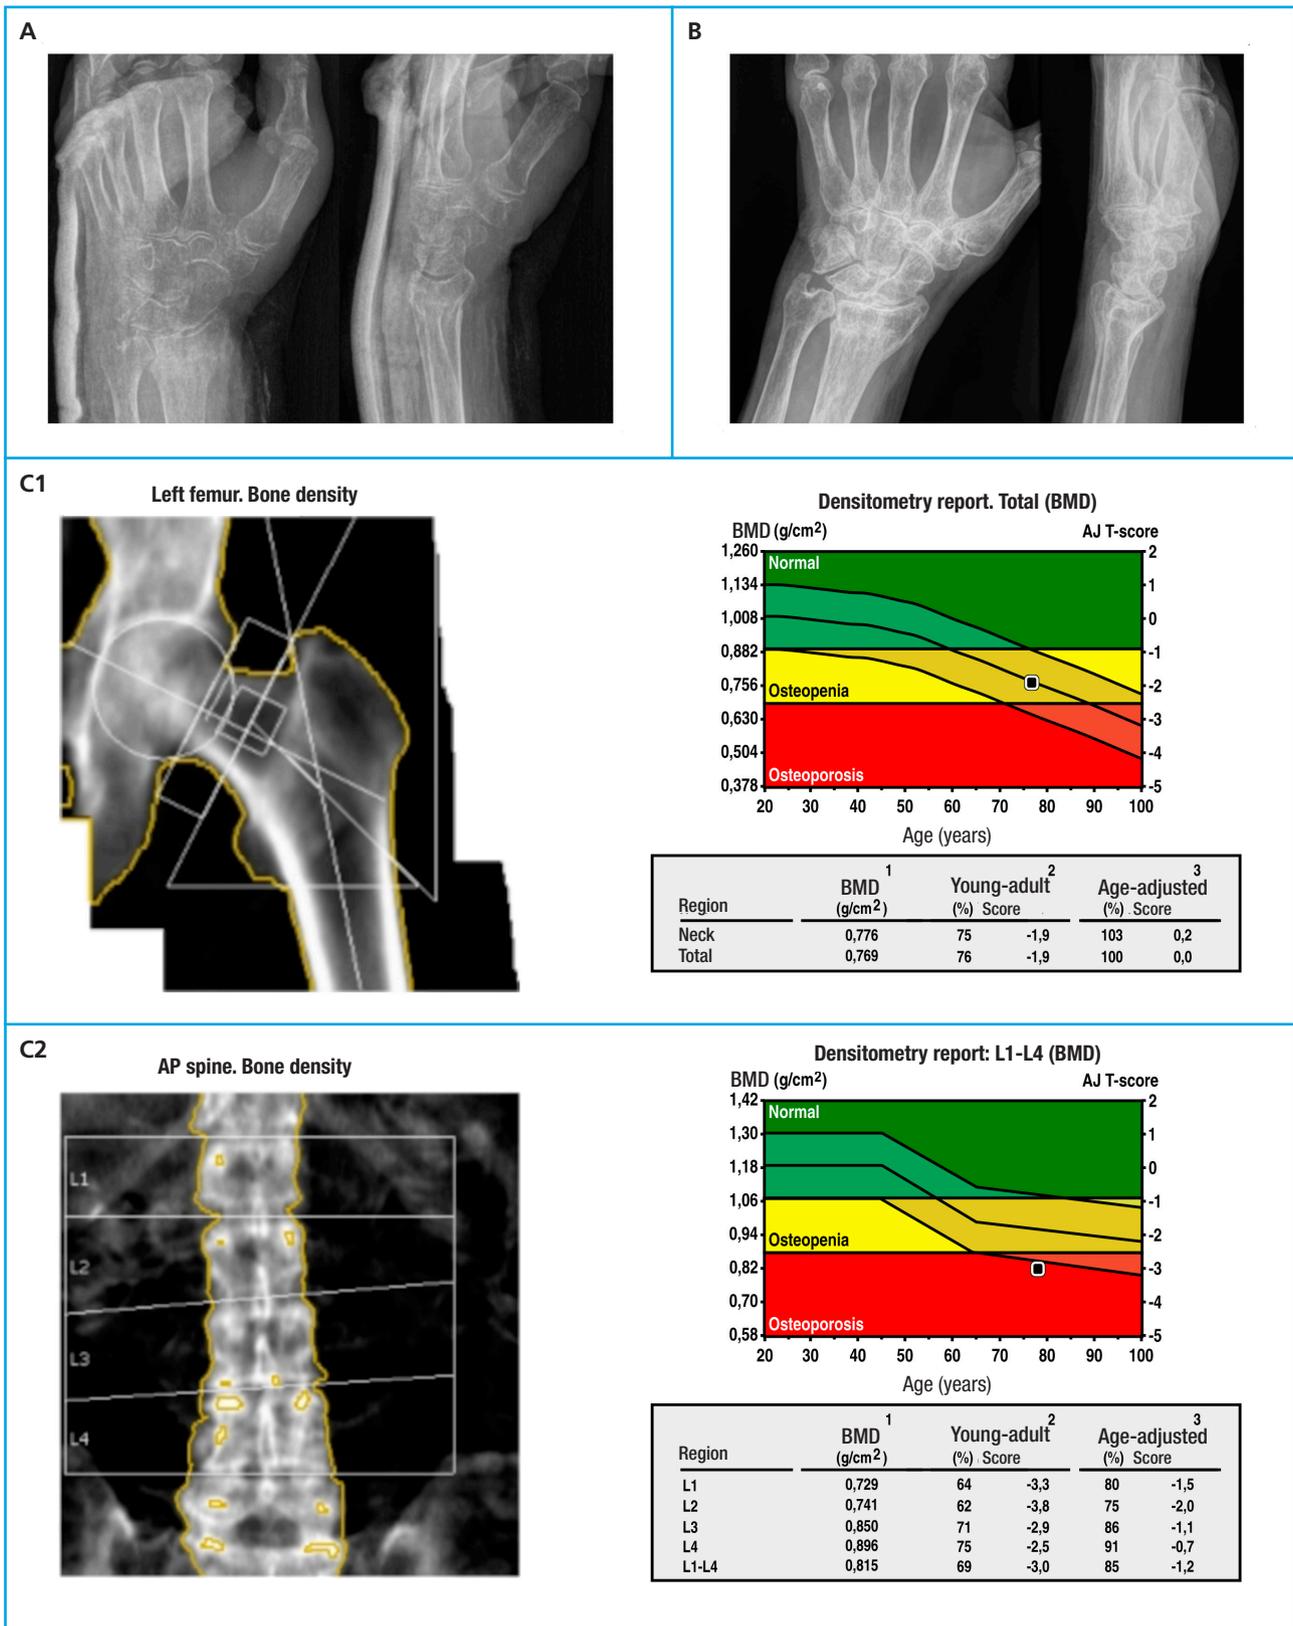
A. Plain radiograph of the left wrist, two projections, follow-up prior to removal of dorsal forearm plaster splint immobilization: distal radius fracture with intra-articular involvement, degenerative changes, and indirect signs of radiocarpal osteoporosis. B. Follow-up radiographic control after three months of treatment: consolidated distal radius fracture. C1. DXA: proximal femur results (osteopenia). C2. DXA: lumbar spine results (osteoporosis).
